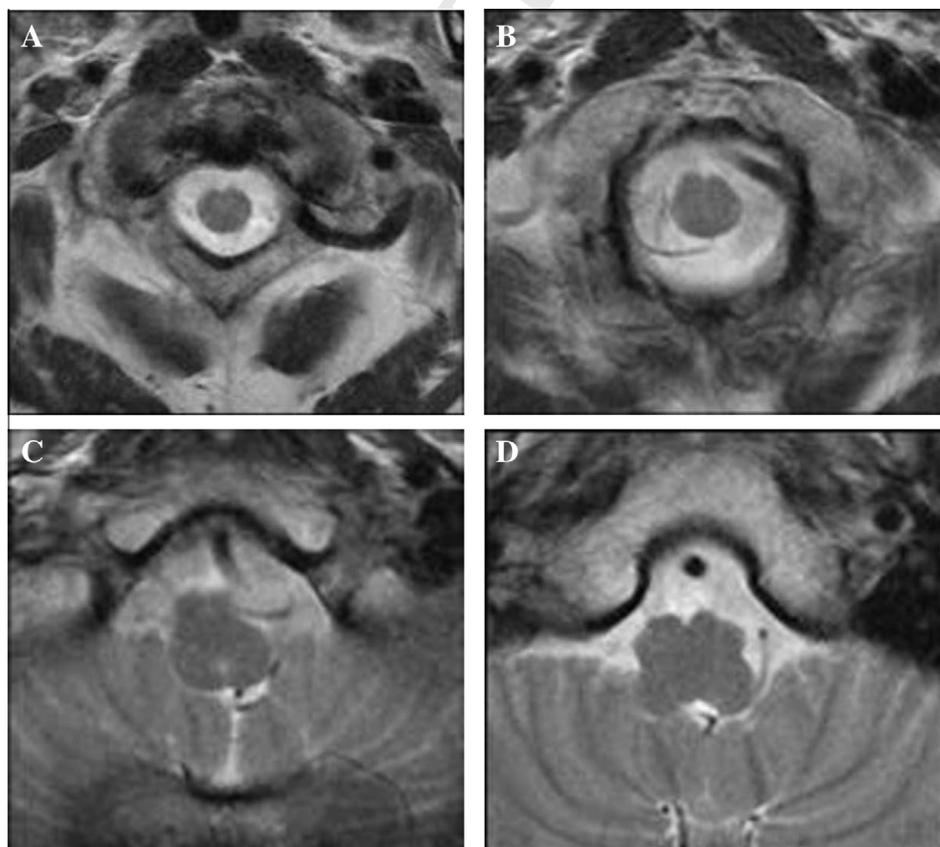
(A–D) Axial T2-weighted magnetic resonance images (consecutive 5-mm slices) demonstrating indentation and lateral displacement of the left side of the lower anterolateral medulla by a loop of posterior inferior cerebellar artery, arising from the dominant left vertebral artery.
